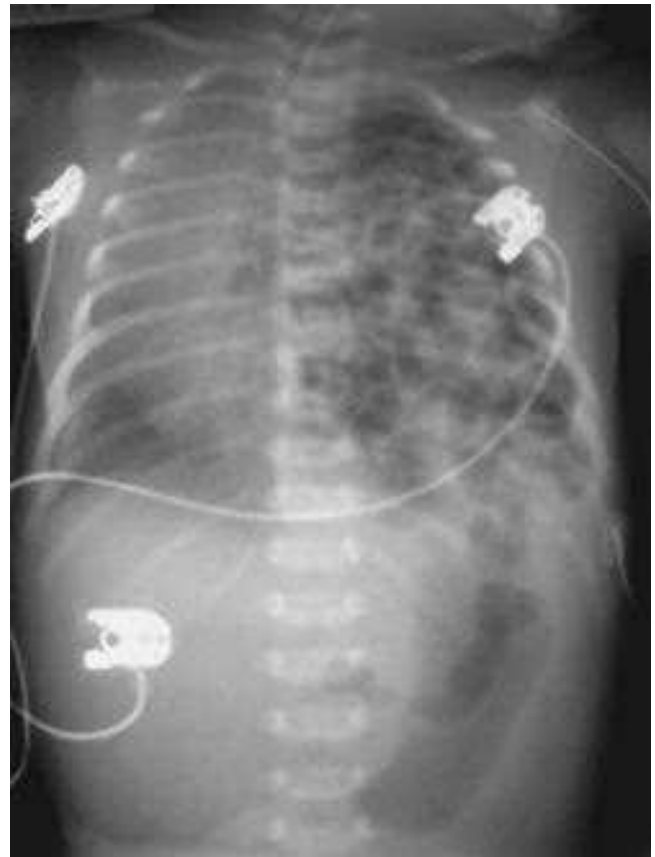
Chest x-ray showing a left congenital diaphragmatic hernia.
